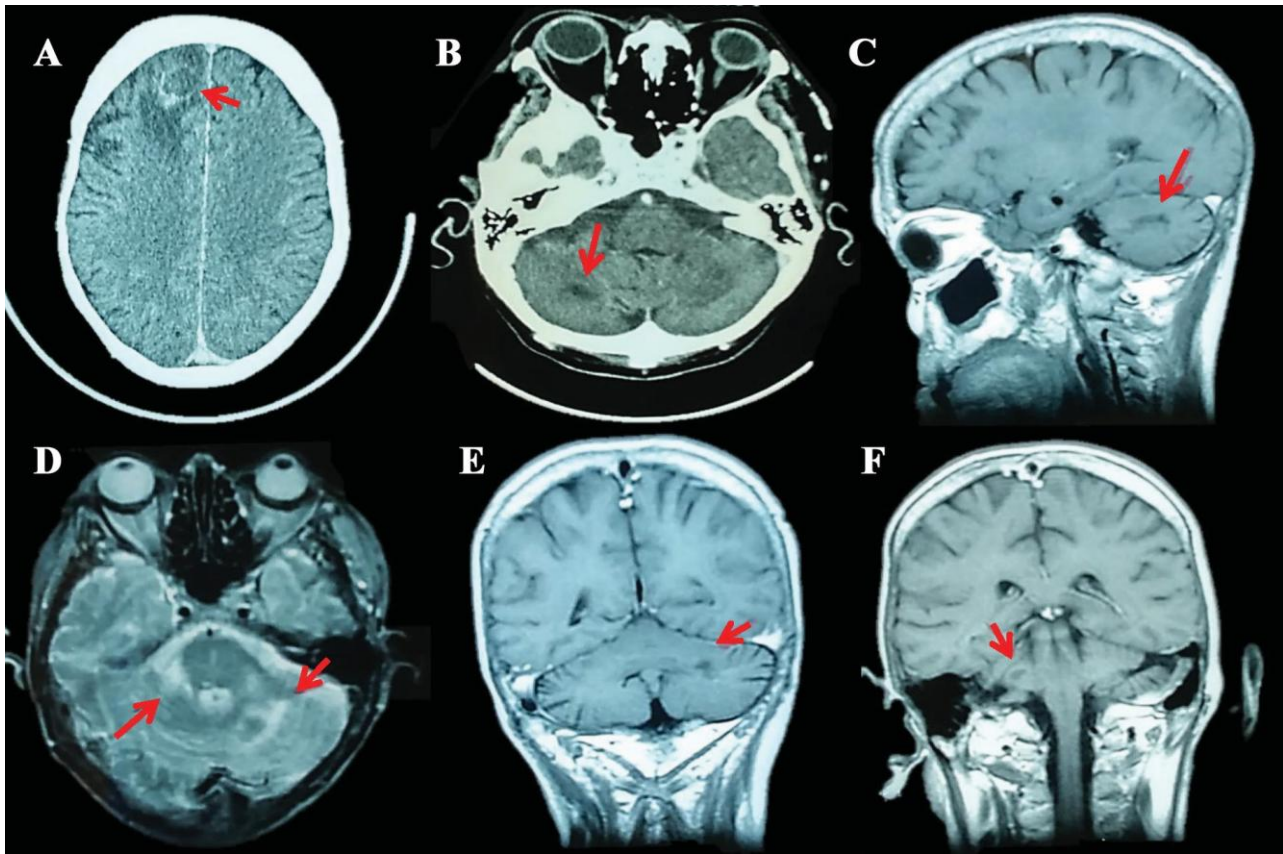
Cranial CT scan (A and B) and MRI (C, D, E and F): (A and B): A) Hypodense lesion with peripheral uptake and perilesional edema in the right frontal lobe compatible with abscess. B) Hypodense lesion localized in the right cerebellar hemisphere, with nodular aspect, without clear enhancement after administration of contrast that suggests an infectious lesion. (C, D, E and F): Lesions localized in both cerebellar hemispheres, hypointense in T1 sequences (C and E) and hyperintense in T2 sequences (D), with peripheral uptake after the administration of gadolinium (G), in relation with abscesses.
